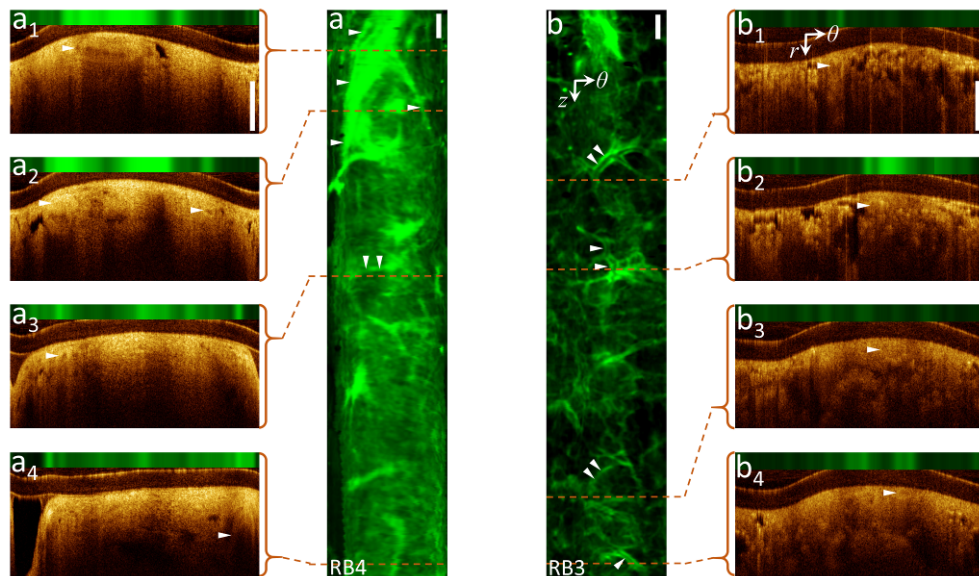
Vascular network visualization by AFI without OCT Doppler contrast: (a, b) AF z - θ maps of pullbacks from airway RB4 and RB3, (a_{1-4} , b_{1-4}) cross-sectional OCT-AFI in polar coordinates (r , θ) corresponding to the red dashed lines along pullbacks. Supplement files [Visualization 1](#) and [Visualization 2](#) include full OCT-AFI pullback scans of (a) and (b). \blacktriangleright indicate vessel locations. Scale-bars are 1mm.
